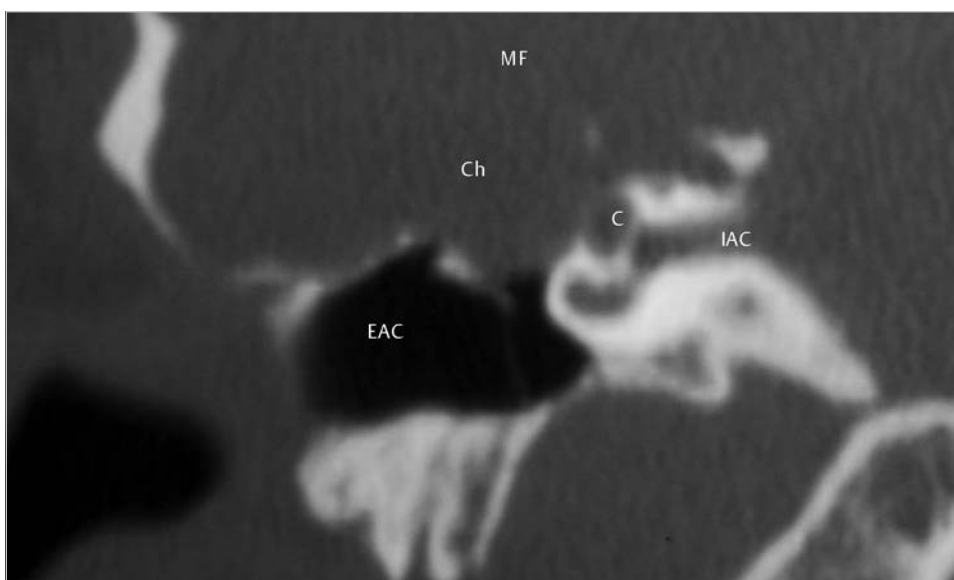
The coronal CT shows severe erosion of the otic capsule and extensive extension of the cholesteatoma medially to the labyrinth. C, cochlea; Ch, cholesteatoma; EAC, external auditory canal; IAC, internal auditory canal; MF, middle fossa.
